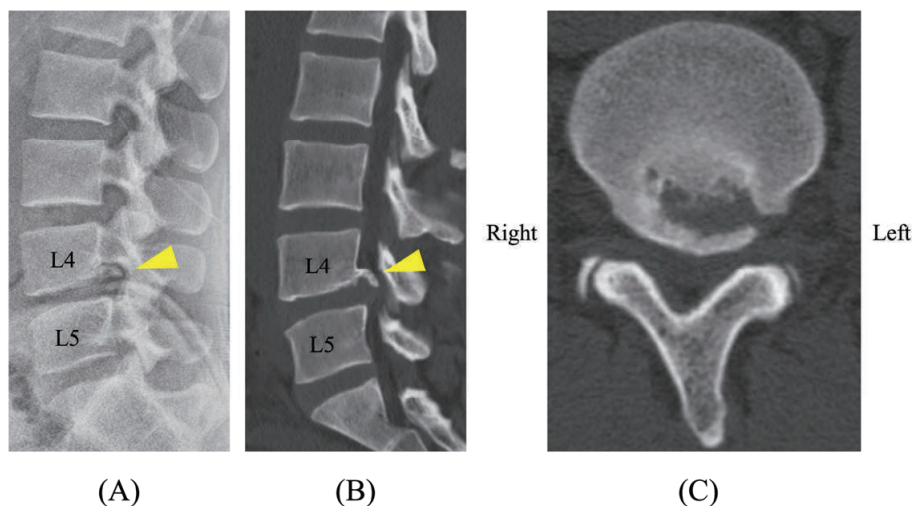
(A) Lateral plain radiograph and (B, C) sagittal and axial views from a non-contrast CT scan performed at our hospital. A ring apophysis fracture extending posteriorly from the L4 vertebral body is visible (yellow arrowhead).
